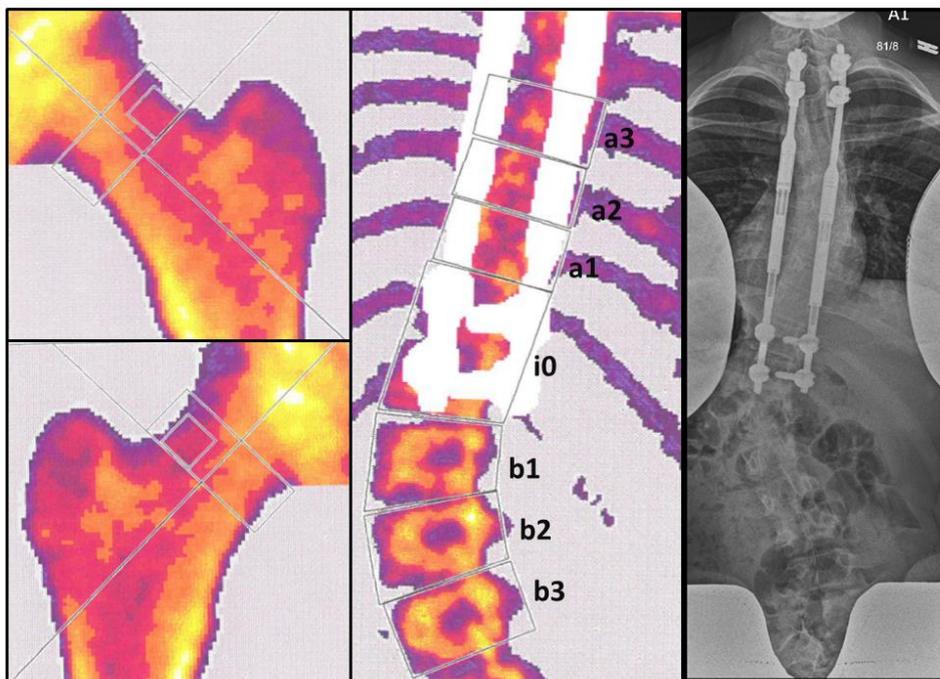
Areal bone mineral density (aBMD) measurements in a 14-year-old girl diagnosed with idiopathic EOS and treated with magnetically controlled growing rods. To the left: aBMD of left and right total hip; Middle: aBMD of the spine with the zones of interest: Vertebrae within the instrumentation (zone a1-3), at the lower anchor point (i0) and vertebrae below the instrumentation (zone b1-3); To the right: Anterior-posterior radiograph at the time of examination showing a major curve of 40 degrees.
